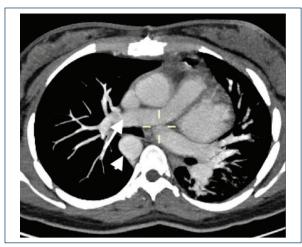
Axial CT Angiography shows normal right pulmonary artery (white arrow) with no left pulmonary arising from the pulmonary trunk and right-sided aorta (Arrowhead).
